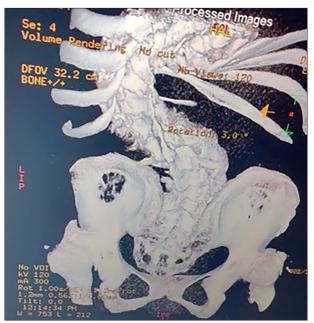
MRI findings of DD patient: Scoliosis (4th grade), osteochondrosis, spondyloarthritis of the spine. Protrusions of disks C3-C4, C4-C5, C5-C6, C6-C7, L5-S1
